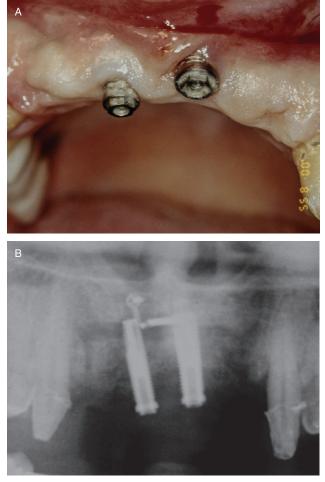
A*, When the bone reached the desired position, each distraction rod was removed and replaced with a implant fixture. Note, one fixture was placed to the buccal in order to keep the bone in a labial position. *B*, Radiograph revealing the two stabilizing implant fixtures held the distracted bone in place.
